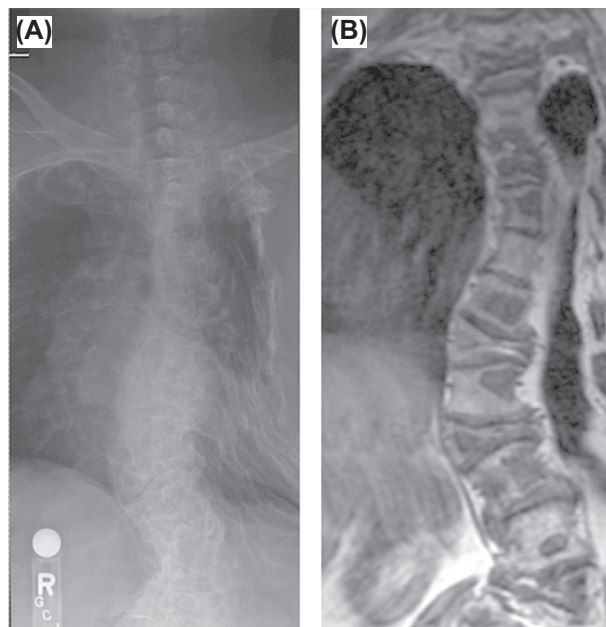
Scoliosis in FD. Scoliosis of the spine is demonstrated in (A) an X-ray and (B) magnetic resonance imaging (MRI) of the spine in a 54-year-old woman with FD. The extent of the involvement of the vertebral columns with FD is demonstrated in the MRI, where large parts of the vertebrae are shown to be replaced with FD. Surprisingly, and typically, the woman had neither pain nor any evidence of neurological compromise, despite extensive disease and multiple compression fractures.
